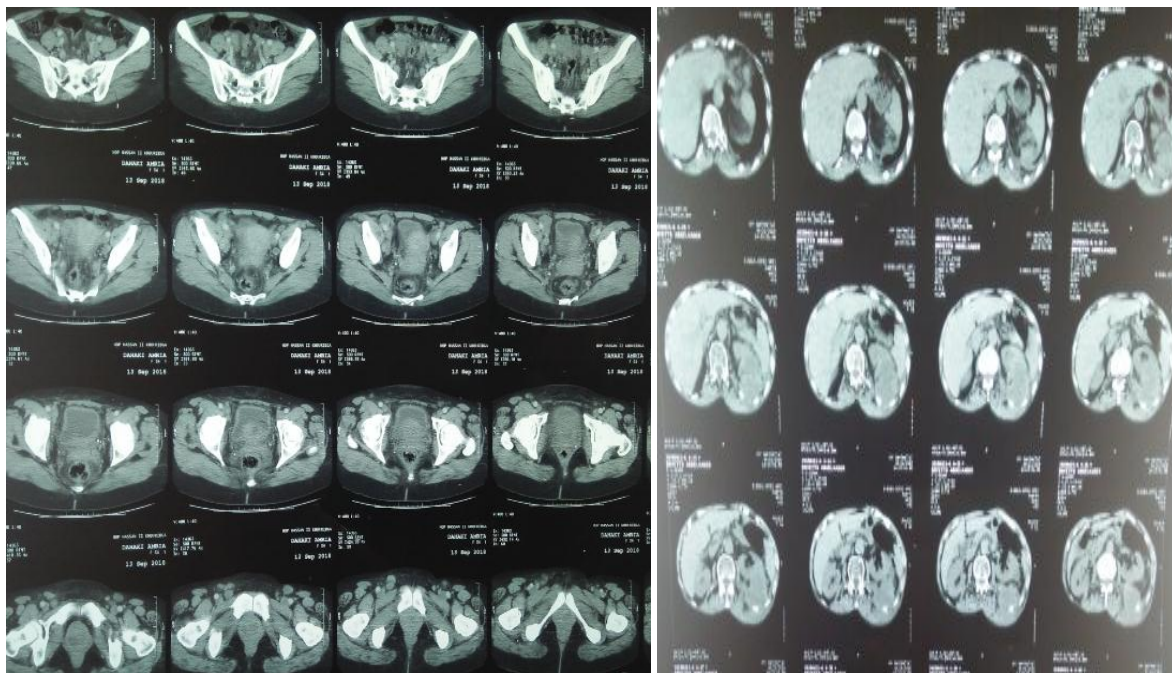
CT scan demonstrated a large urethral mass with abdominal and pelvic lymphadenopathy and secondary hepatic lesions.
